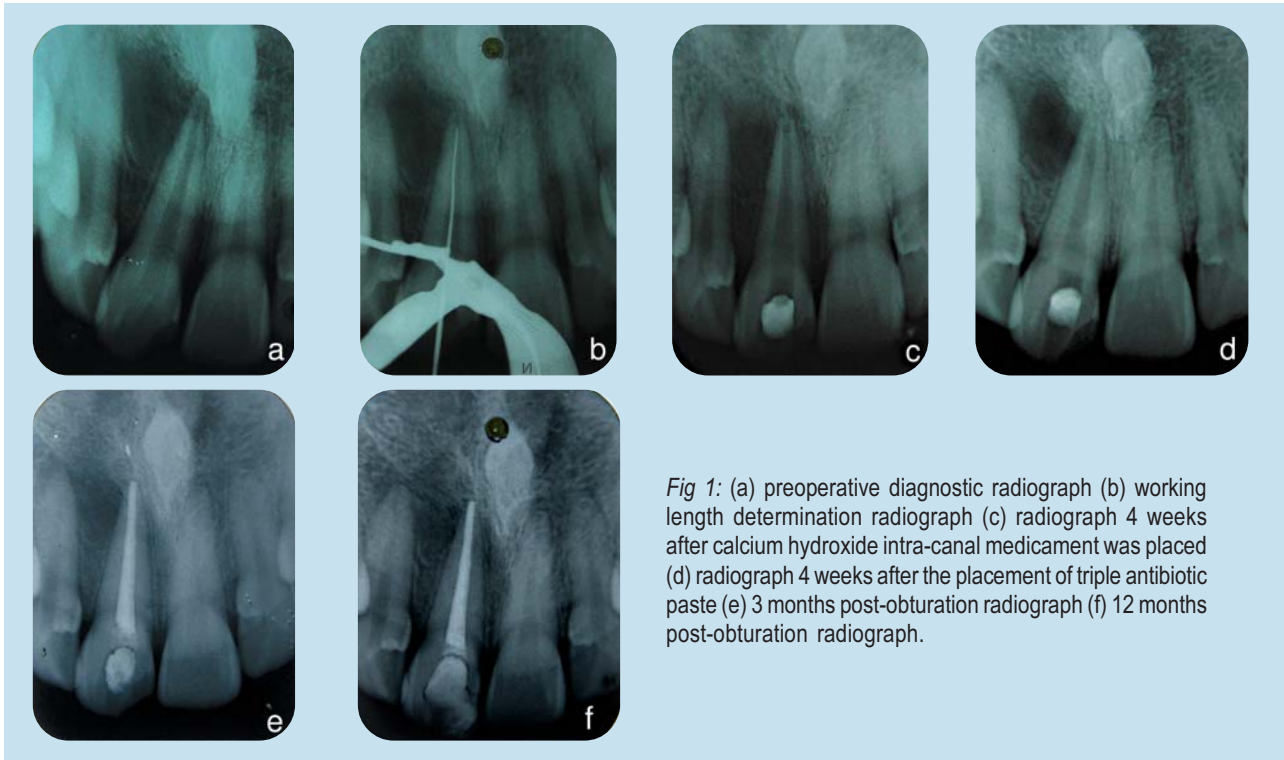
(a) preoperative diagnostic radiograph (b) working length determination radiograph (c) radiograph 4 weeks after calcium hydroxide intra-canal medicament was placed (d) radiograph 4 weeks after the placement of triple antibiotic paste (e) 3 months post-obturation radiograph (f) 12 months post-obturation radiograph.
